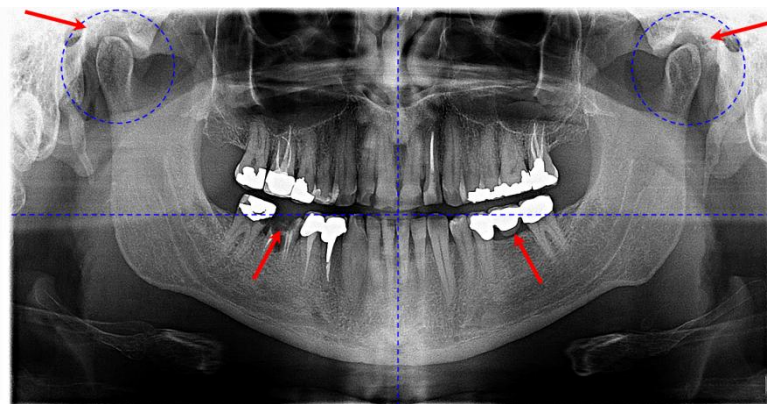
X-ray: Occlusal plane of the person. Arrows indicate temporomandibular joint changes and occlusal misalignment.
